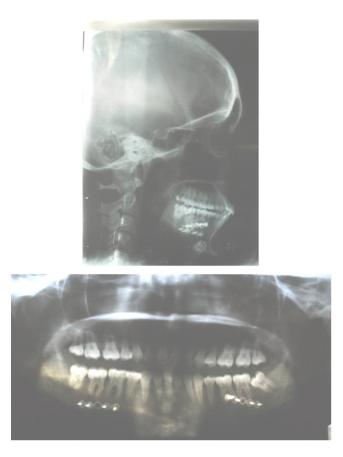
Post Treatment Radiographs – Lateral Cephalogram and OPG
